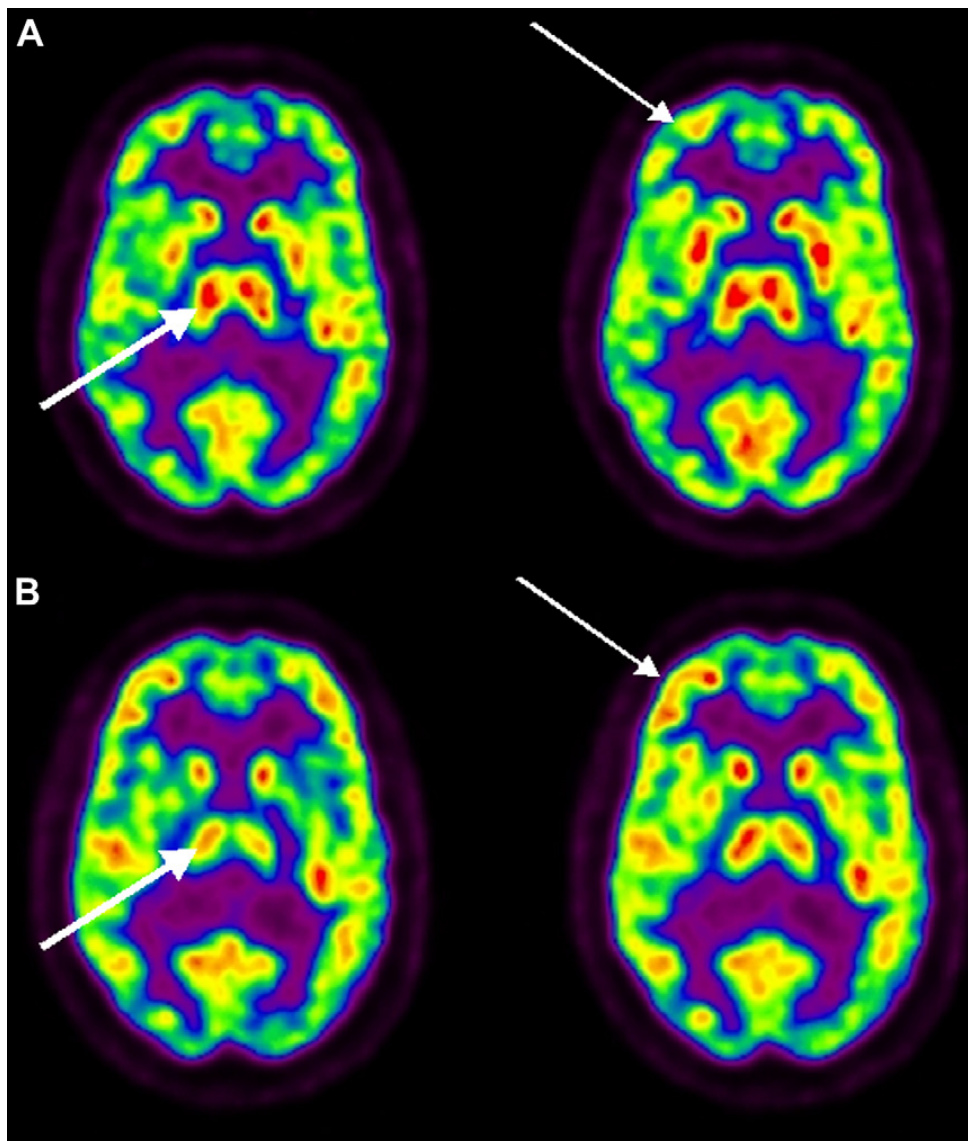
FDG-PET scans of a subject at rest (A) and while performing a meditation task (B). During meditation, there is increased metabolism in the frontal lobes (*thin arrow*) and decreased metabolism in the thalami (*thick arrow*). These structures are involved in stress pathways and the observed effects in these scans are hypothesized to be associated reduced levels of stress and anxiety.
